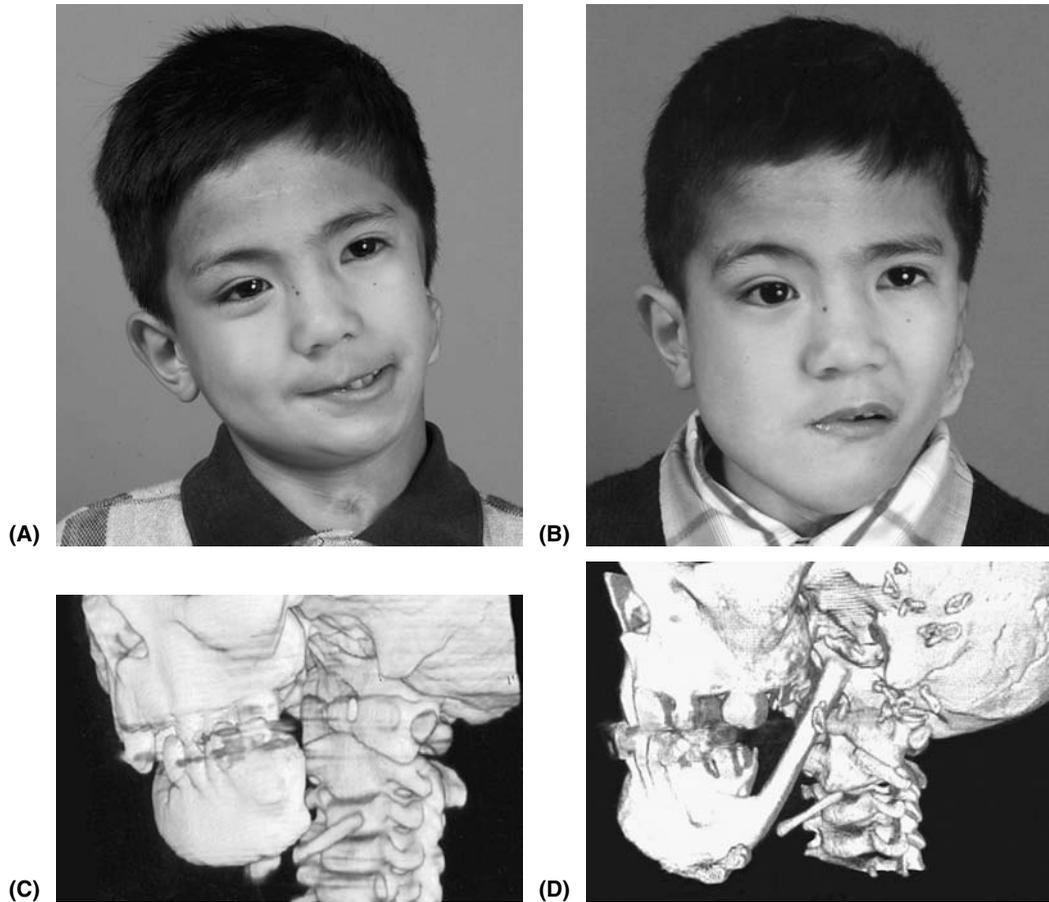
Images of a patient with left Goldenhar syndrome. (A) Preoperative image demonstrates severe left mandibular hypoplasia. (B) Postoperative image following a costochondral rib graft shows improved chinpoint position. (C) Preoperative computed tomography (CT) scan demonstrates a Pruzansky type III mandible with no ramus or temporomandibular joint. (D) Postoperative CT scan shows consolidated rib graft.
